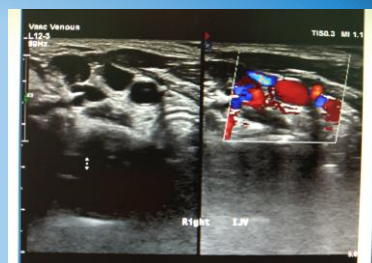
Ultrasound findings shows marked increase in size of right internal jugular vein during Valsalva manoeuvre
